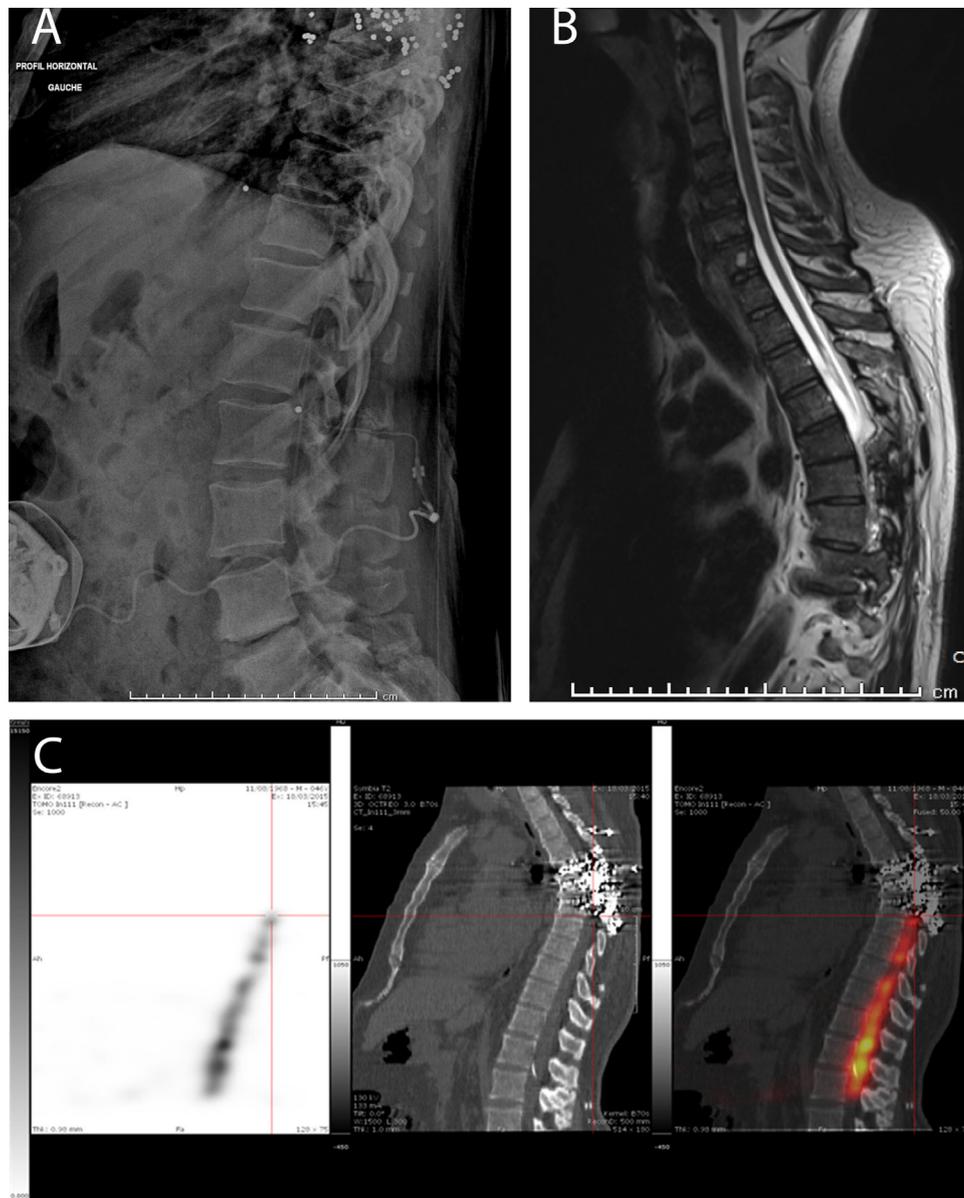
A. Abdominal X-ray. The pump is in the anterior abdominal position, and the catheter enters the subdural space between L1–L2. The top extremity of the catheter is in the Th11 position. No disconnection of the device is seen on this radiograph. B. MRI of the spine in medial sagittal plane. FLAIR imaging shows an intramedullary hyperintense signal at Th3 and Th4 vertebrae, evocative of a syringomelic cyst. The lesional atrophy is visible at Th5–6, with metal artifacts due to gunshot residue below Th6. C. Tomoscintigraphy coupled with CT performed 96 h after ^{111}In -DTPA injection revealing indium activity in the subarachnoid space but sudden interruption of ^{111}In -DTPA at the thoracic level without activity above the lead shot. ^{111}In -DTPA: indium-111 diethylenetriamine pentaacetic acid; FLAIR: fluid-attenuated inversion recovery.
